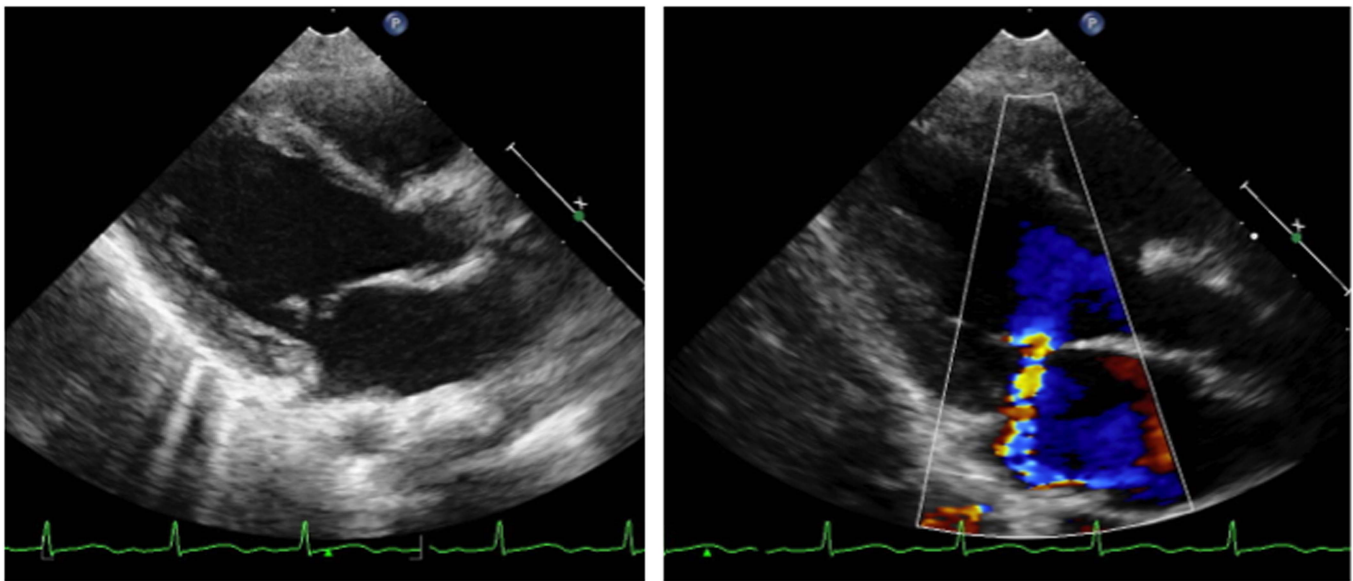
Two-dimensional echocardiogram at 1-year-old in patient 3. (Left) Prolapse of chordae tendineae in the anterior leaflet was detected. (Right) Mitral regurgitation was found. The grade of mitral regurgitation was slight to moderate.
